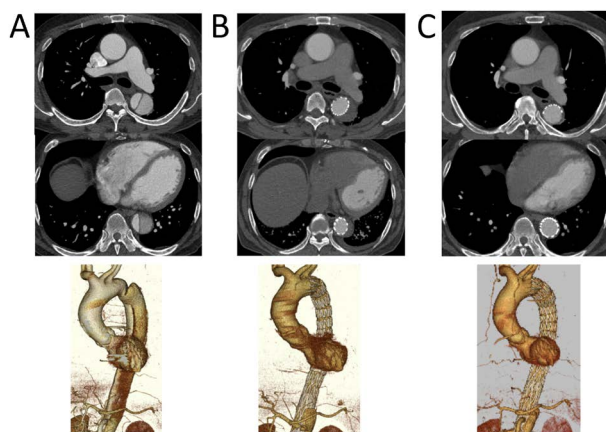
CT images of 51 year-old male diagnosed with subacute uncomplicated type B aortic dissection.
